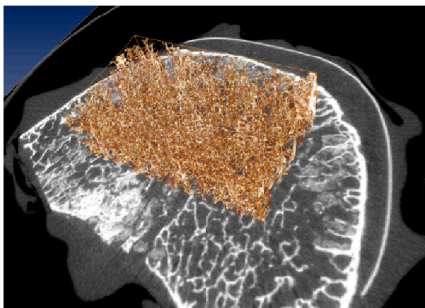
Volume of interest applied to a human lumbar vertebra. Analysed part of the trabecular structure is shown in brown, grey-scale image is the axial CT slice through the middle of the vertebral body.
